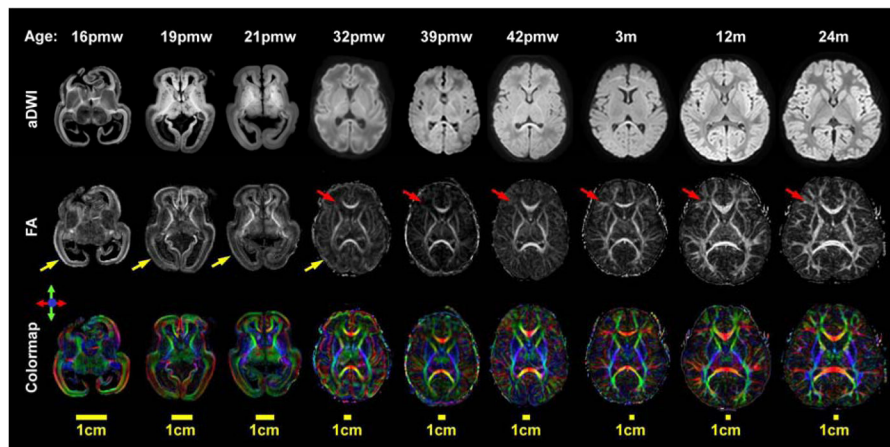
Diffusion MRI (dMRI) contrast in the fetal and infant brain from 16 postmenstrual weeks (pmw) to 2 years (24 months) of age. From top to bottom, axial slices of the averaged diffusion weighted images (aDWI), fractional anisotropy (FA) maps and color-encoded diffusion orientation maps are shown. Yellow arrows indicate high FA values in the cortical plate, and red arrows indicate high FA values in the white matter regions during this early developing period. This figure is generated with the data from Huang lab.
